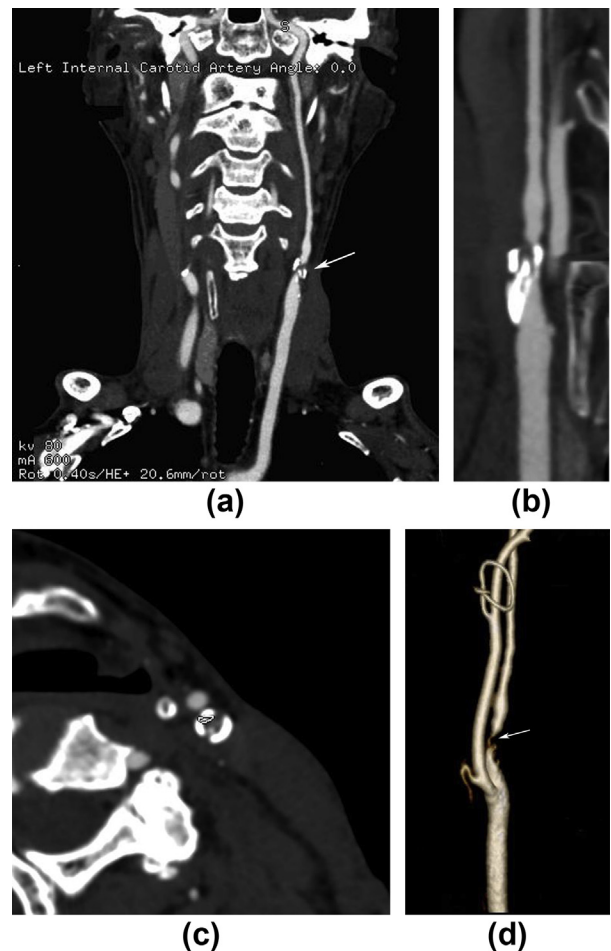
CTA images of a 65-year-old man using 175 mg iodine/kg contrast medium dose, 80 kV, and 600 mAs. (a) MPR image showing mixed plaque of the left internal carotid artery. (b) Vascular image displays mixed plaque clearly, and shows severe left internal carotid artery stenosis. (c) Axial images distinctly show mixed plaque. (d) VR image displayed internal carotid artery stenosis. The degree of stenosis of the left side was approximately 90%.
